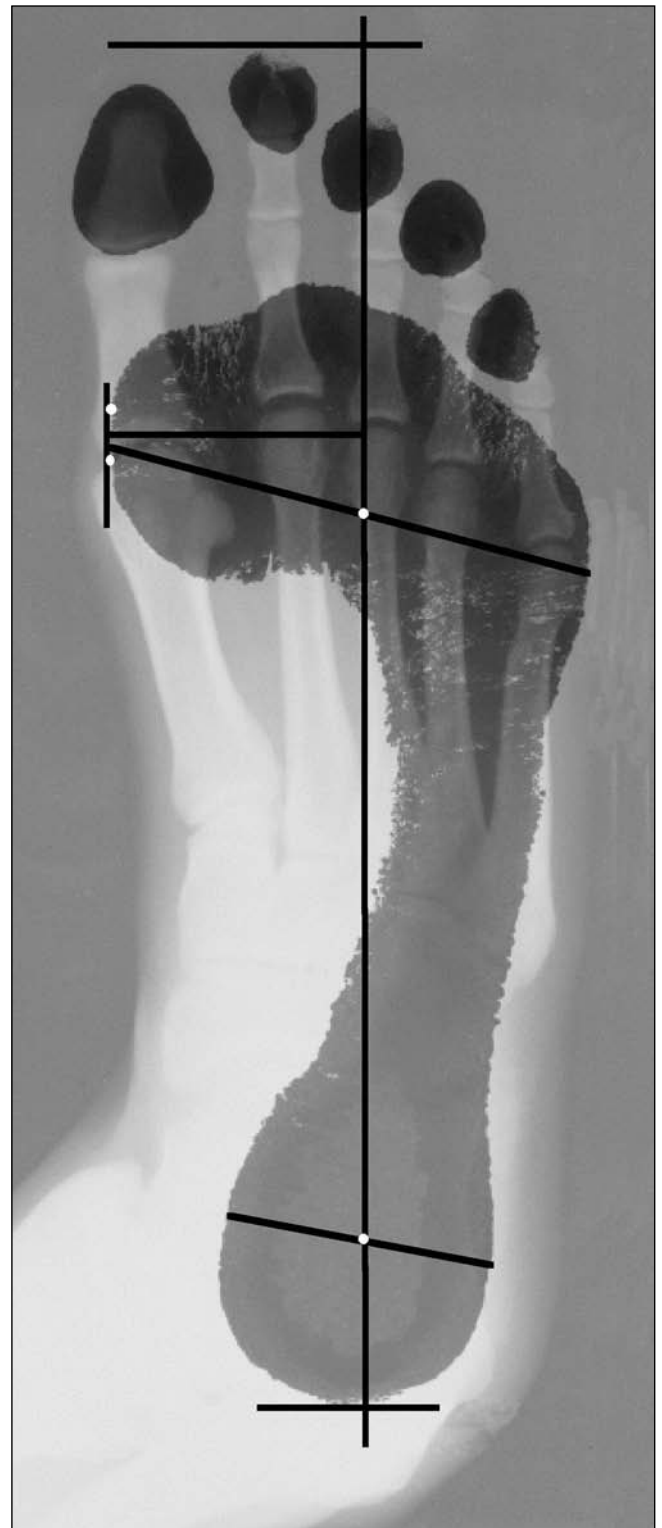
Footprint and measurement lines overlain on a radiograph. The footprint of one subject is superimposed on the radiograph of the same subject's foot. The lines drawn on the footprint are those used by Tuttle *et al.* (1990) and Manley-Buser *et al.* (2001), with two new lines added as described in the new method developed here. Note that the line across the entire ball of the foot (as suggested by previous authors) is proximal to the metatarso-phalangeal joint centres of all but the first and fifth rays.
